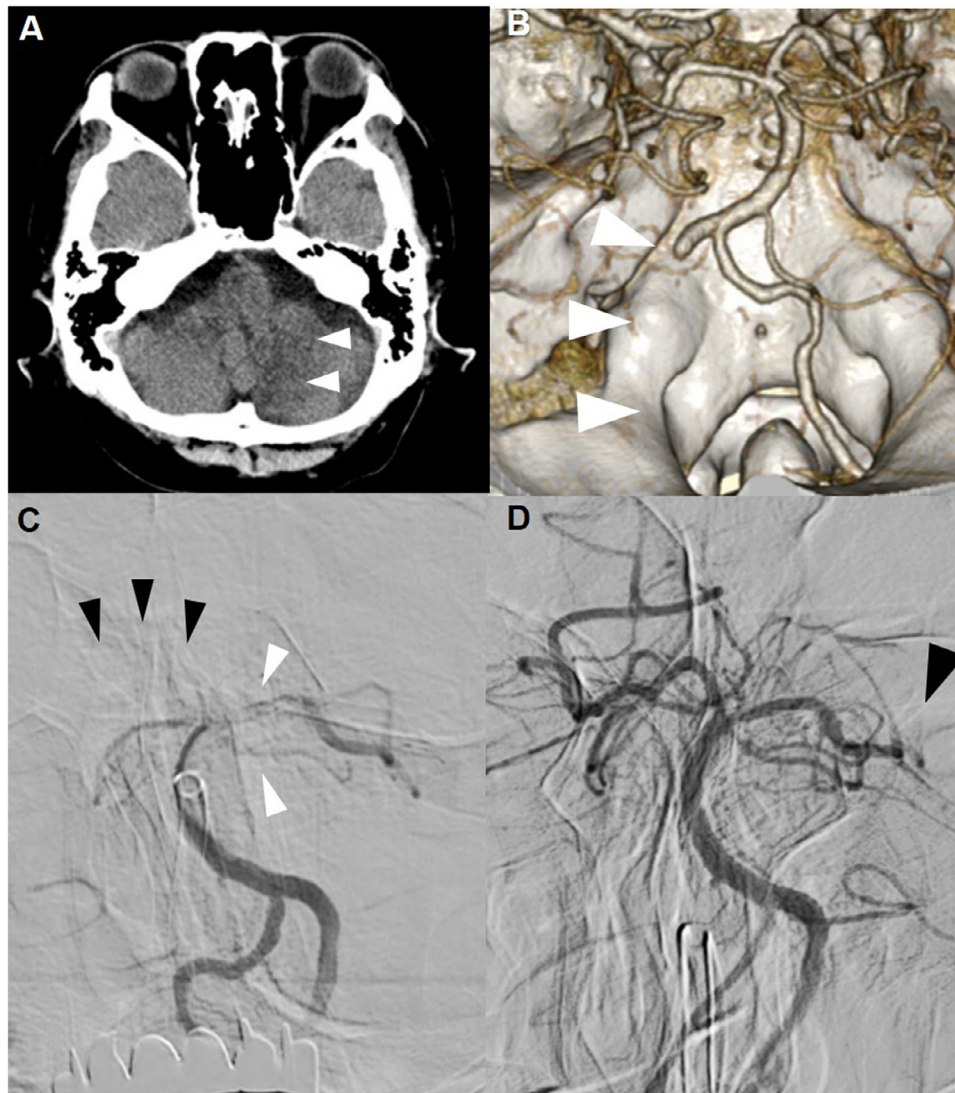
(A) Computed tomography (CT) scan obtained upon arrival showing a low-density lesion in the left cerebellar hemisphere (arrowheads). (B) CT angiography (CTA) showing occlusion of the left vertebral artery (VA) from the V4 segment (arrowheads). (C) Right vertebral injection demonstrating stagnant flow in the left posterior cerebral artery (PCA), the left superior cerebellar artery (SCA) (white arrowheads), and a contrast defect in the right PCA (black arrowheads). (D) Left vertebral injection performed immediately after thrombectomy showing recanalization of the top of the basilar artery (BA) with flow stagnation in the P3 segment of the left PCA (arrowhead).
